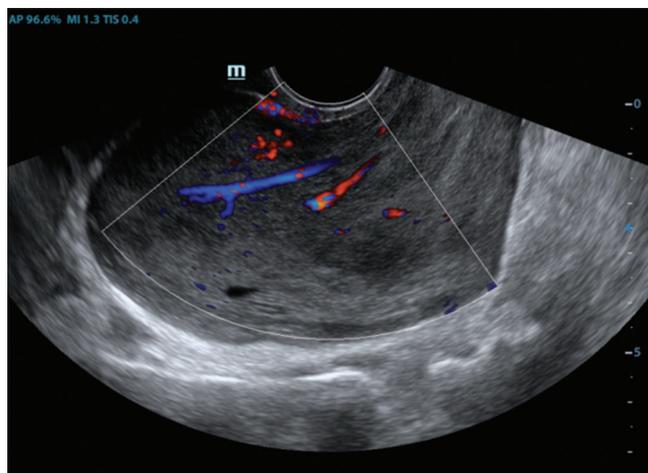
Transvaginal ultrasound showing well-defined homogeneous lesion with traversing vascular channels
